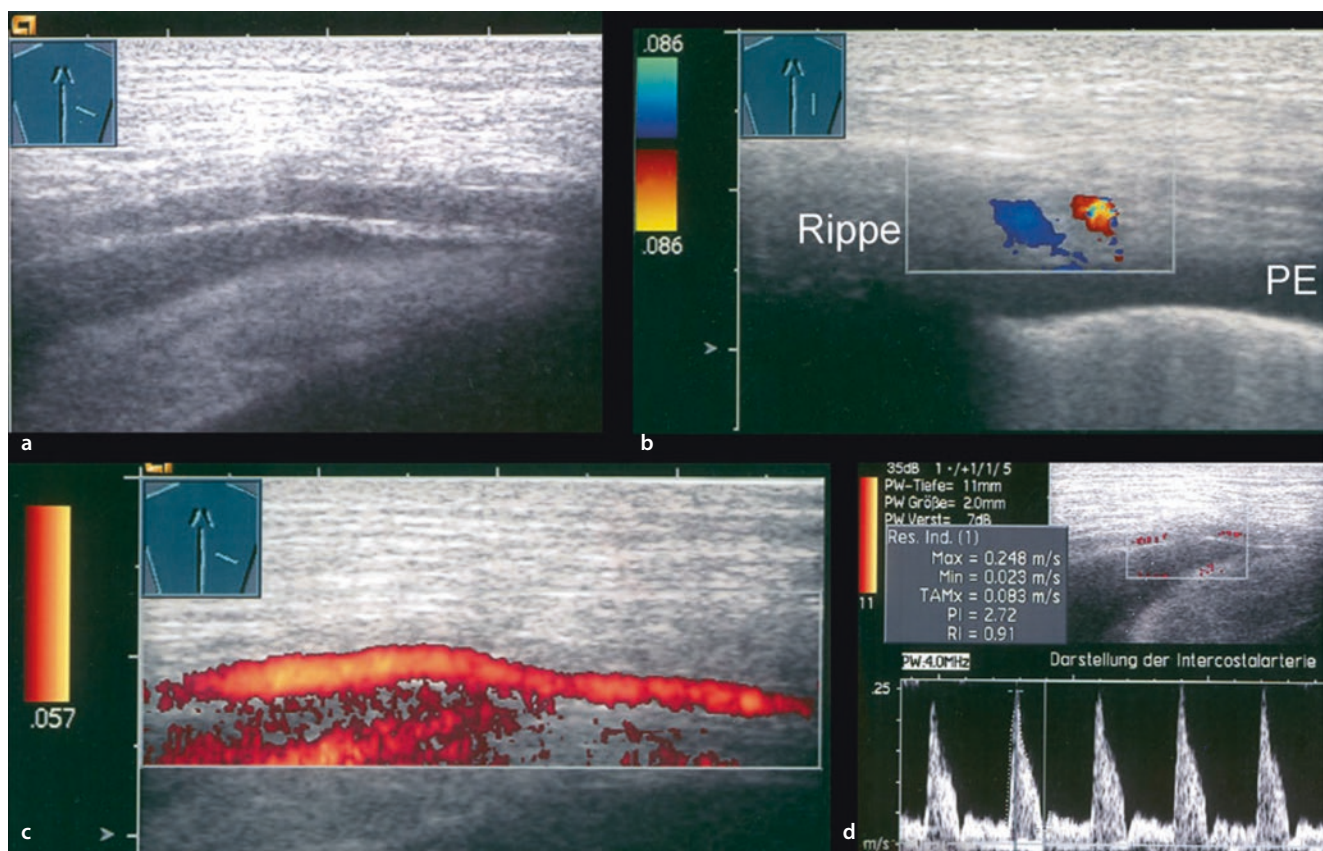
US-Imaging of a normal intercostal artery. a Visible in B-Mode-Scan in intercostal section. b craniocaudal scan. c Color Doppler imaging of the intercostal arteria in longitudinal scan.
